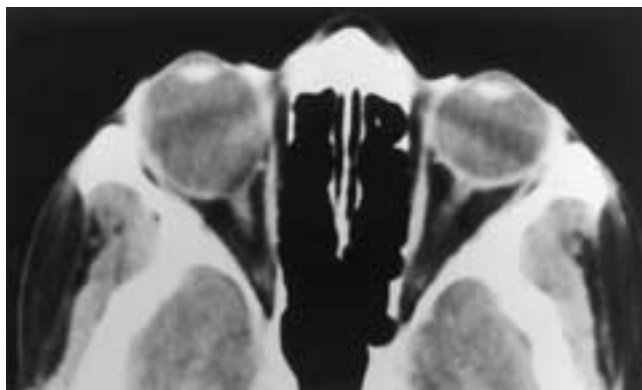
Axial myopia and staphyloma. Axial CT scan shows marked enlargement of the right globe associated with thinning of the sclera and bulging of the posterior globe including the peripapillary region.
